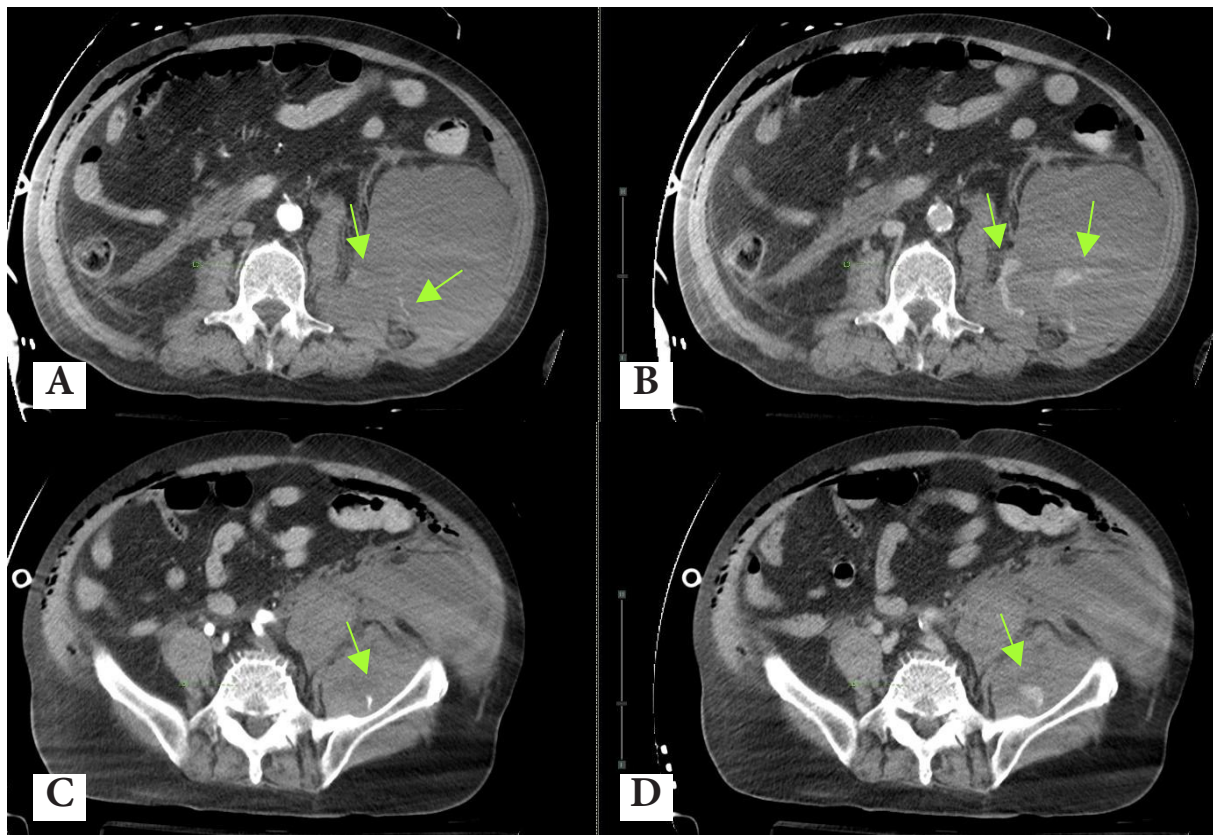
CT whole abdomen axial view arterial phase (A, C) and portovenous phase (B, D), a 68-year-old male, a known case of COVID-19 infection, given Enoxaparin thromboembolic treatment and developed active bleeding at left iliacus, left iliopsoas muscle (A, B) with large retroperitoneal hematoma (C, D). Angiography showed contrast extravasation along the territory of the left L3 and L4 lumbar arteries, and the left iliolumbar artery (arrow). He underwent gelfoam embolization.
